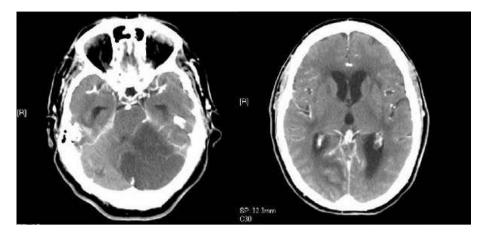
Axial CT scan of the brain showing extensive left cerebellar infarction (on the left side) and supratentorial ventricular dilatation (on the right side).
